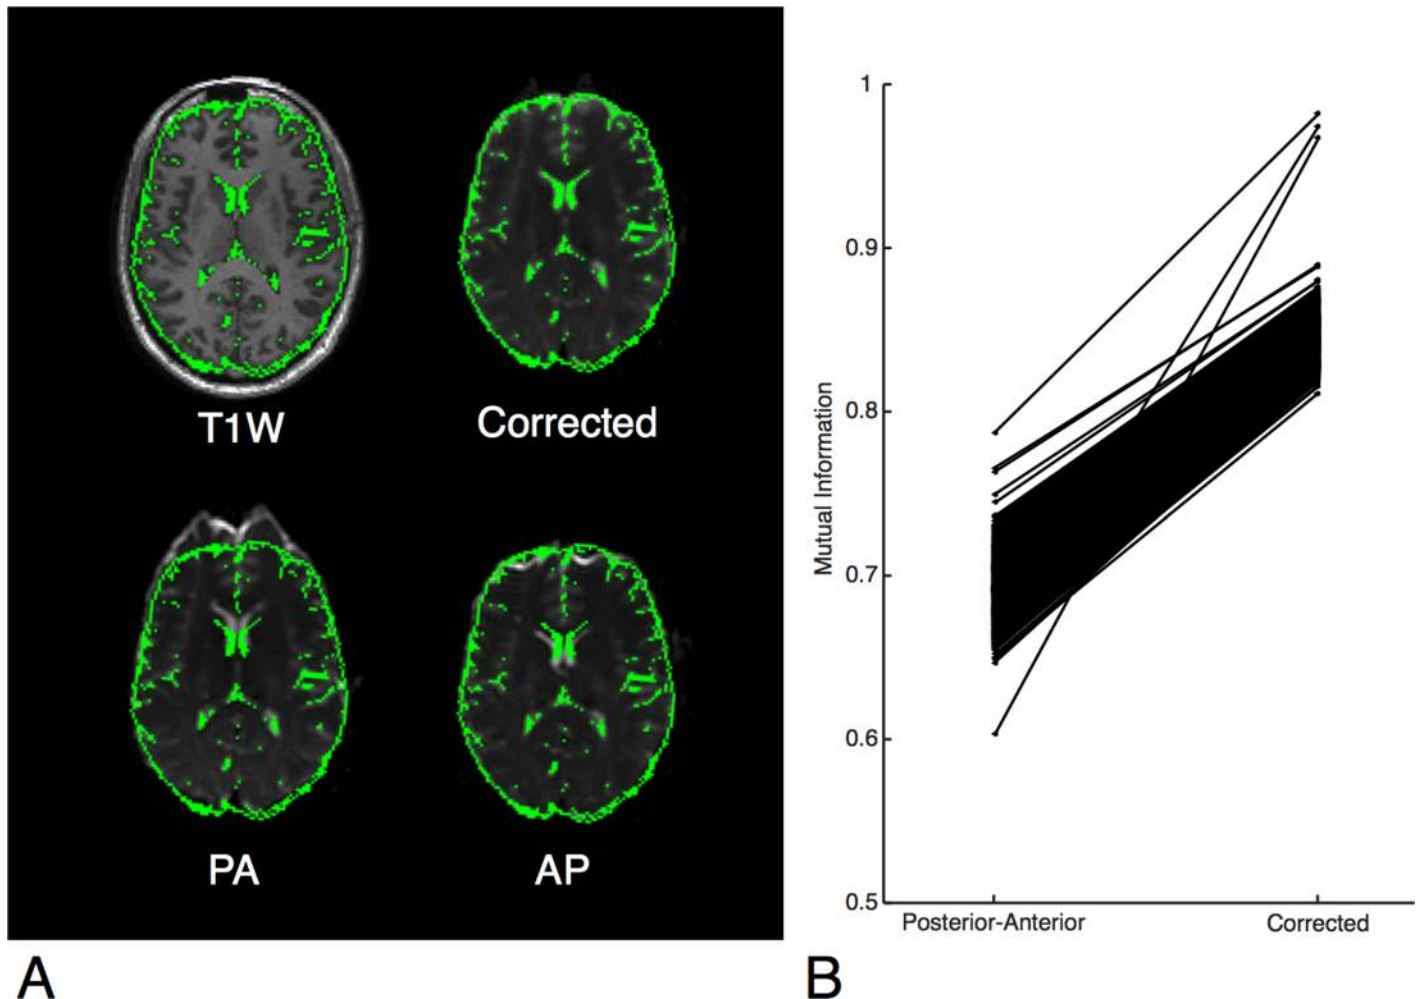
A: Demonstration of the algorithm on a single subject. A mask of the CSF created from the T1W is shown overlaid in green. Top left, subject's T1-weighted MRI image. Top right, subject's corrected $b = 0$ image. Bottom, subject's uncorrected $b = 0$ image in both encoding directions is shown, posterior-anterior (PA) and anterior-posterior (AP). The CSF is shown to fit the boundaries of the corrected $b = 0$ image but not the uncorrected images. This effect is most pronounced in the frontal lobe and anterior aspect of the lateral ventricles. B: Mattes mutual information calculated between the T1W and $b = 0$ images. In all 814 imaging series, the corrected $b = 0$ image was more similar to the T1W image than the uncorrected $b = 0$ image.
